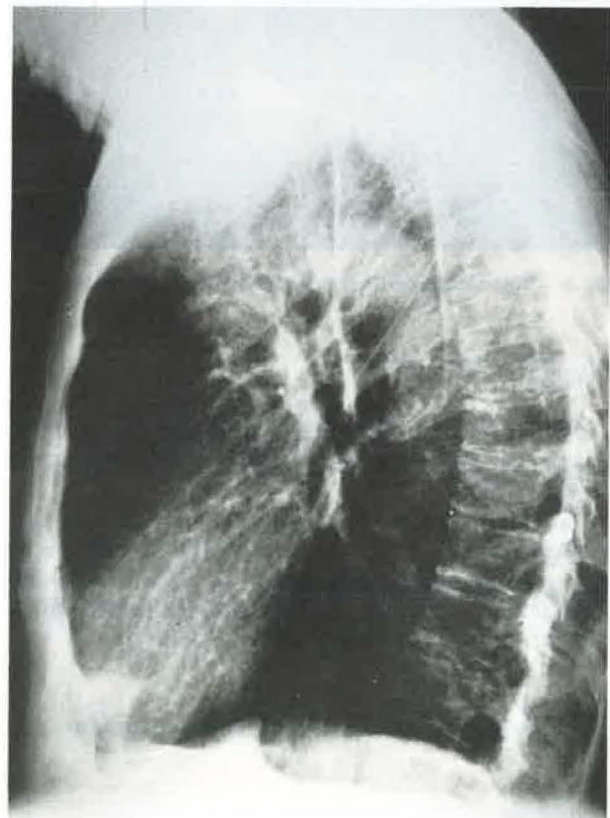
Lateral chest roentgenogram.
